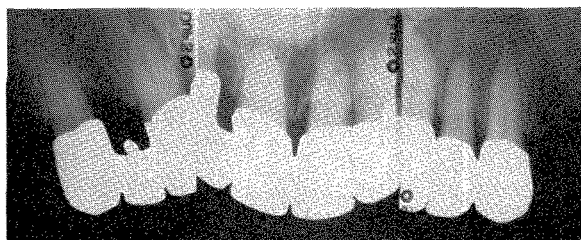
The roentgenograms of the completed new splint.
